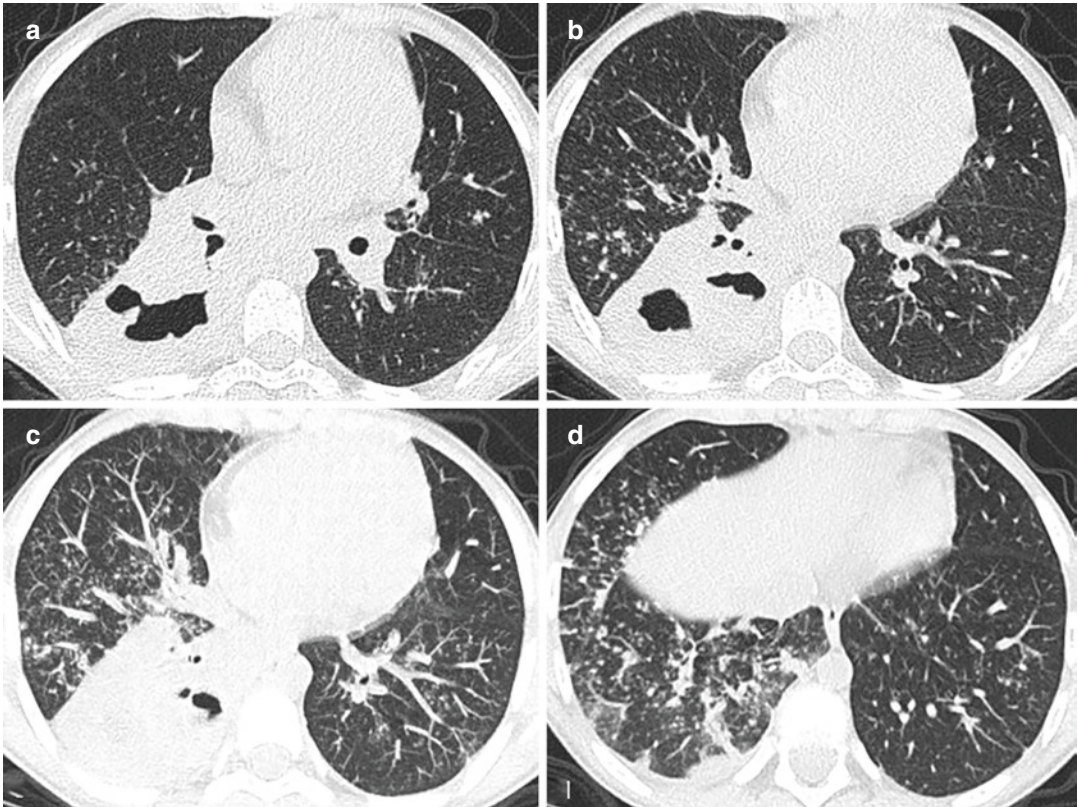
Nocardiosis in an 11-year-old patient with a history of chronic septic granulomatosis. (a and b) Axial CT images show multiple cavitating consolidations in the right lower lobe without obvious communication with the bronchial tree. (c and d) Axial MIP-reconstructed CT
